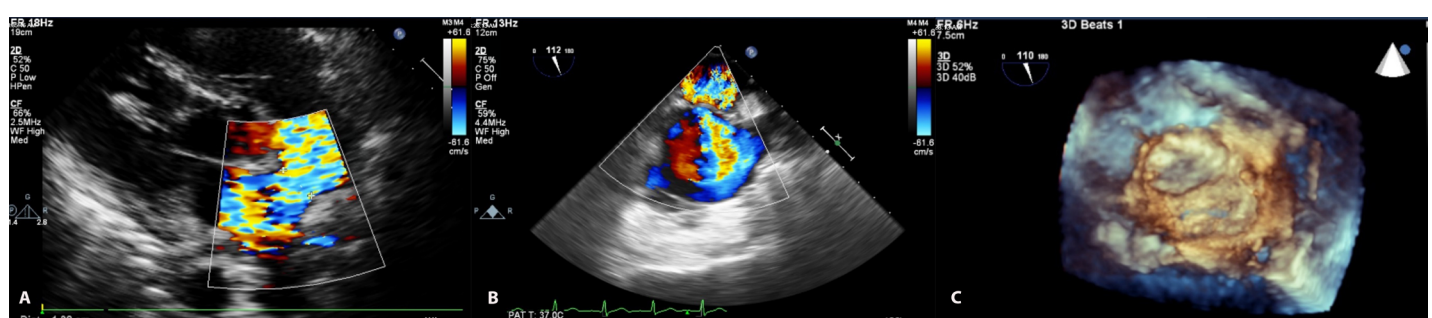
Postoperative TTE and TEE images. A: Modified subcostal plane imaging demonstrated large interatrial defect after surgery. B: Modified bi-caval view demonstrated left to right shunt after surgery. C: 3-Dimensional reconstruction demonstrated a slit-like defect in IAS. Abbreviations: TTE: Transthoracic echocardiography, TEE: Transesophageal echocardiography, IAS: interatrial septum.
